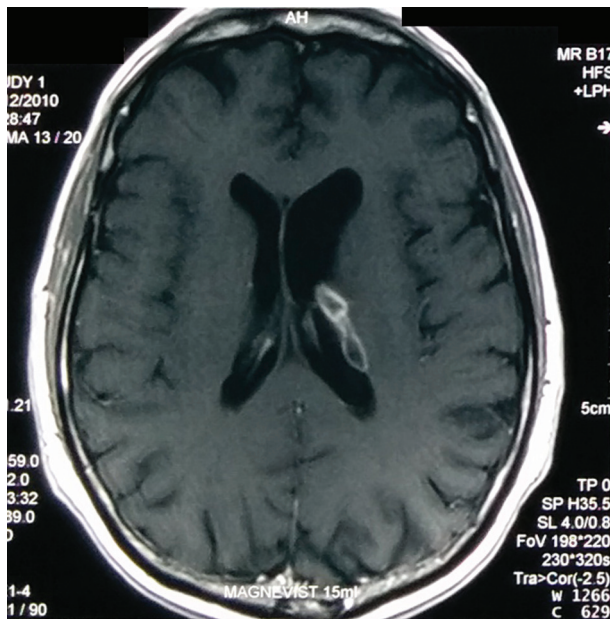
Gadolinium-enhanced MRI of the brain (during the patient's previous admission) had revealed a multilobular, peripheral-enhancing mass on the rim of the left lateral ventricle, consistent with a row of cerebral abscesses.
